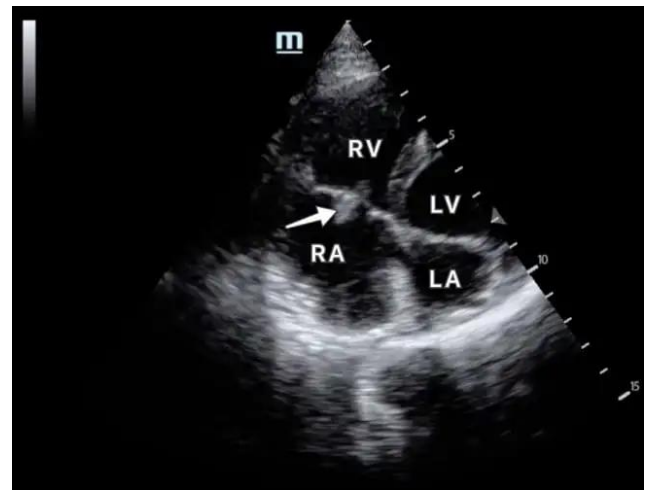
Infective Endocarditis identified on the tricuspid valve on transthoracic echocardiography in the apical 4 chamber view (Identified by the white arrow). RA (right atrium), RV (right ventricle), LA (left atrium) and LV (left ventricle) [67].
